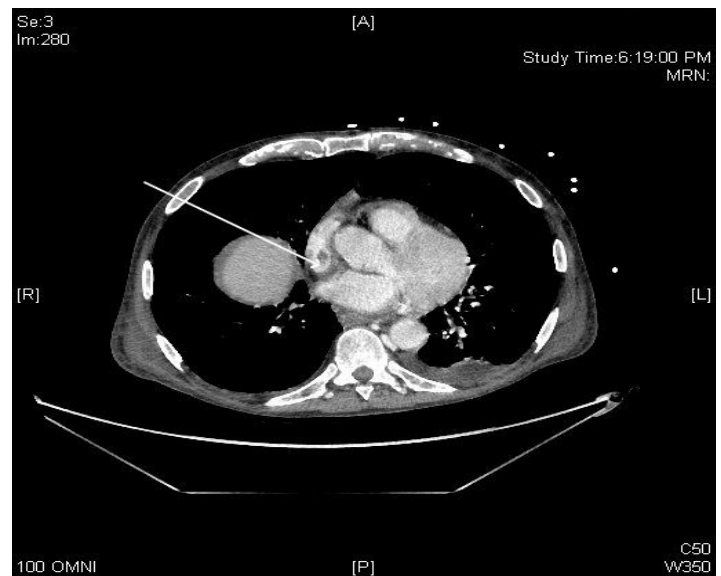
Computed tomography image demonstrating filling defect in SVC distal to central venous port tip (arrow). SVC, superior vena cava
